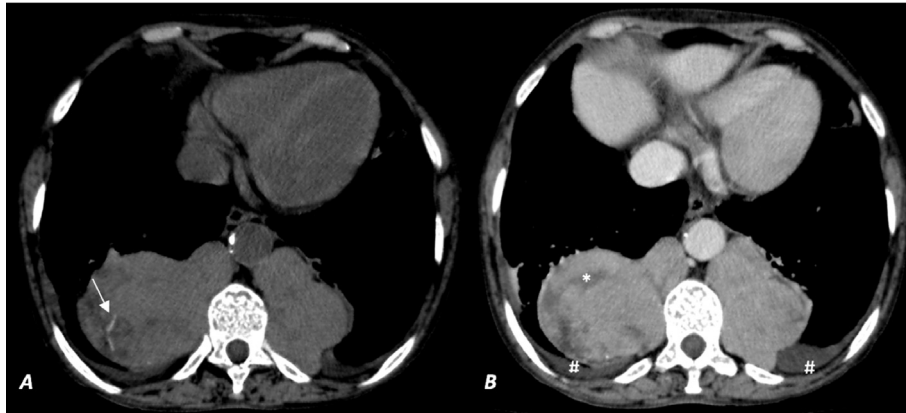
CT scan. A (pre-contrast) and B (post-contrast) shows lobulated paravertebral masses with mild enhancement, linear calcification foci (arrow) and areas of fat attenuation within (*). A small pleural effusion (#) can be seen in both sides.
